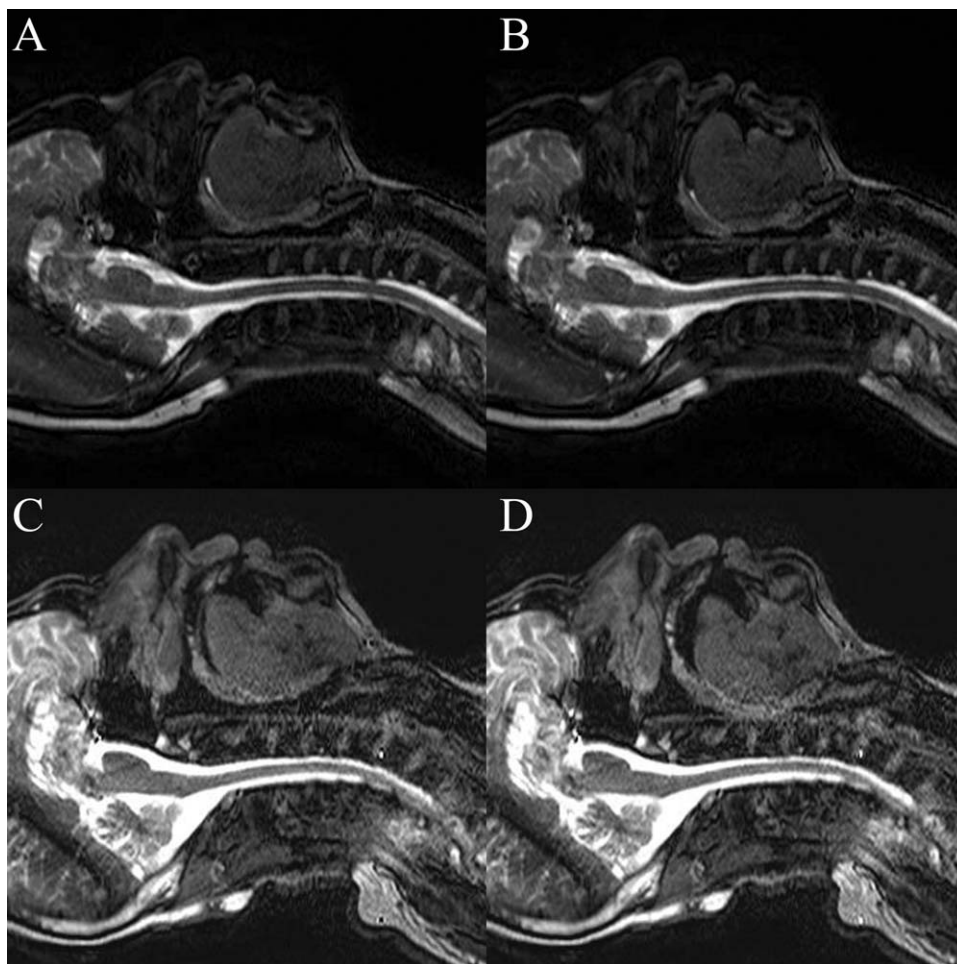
Midsagittal magnetic resonance images of upper airway obstruction at the retropalatal level only (A, B) and at both the retropalatal and retrolingual levels (C, D).
